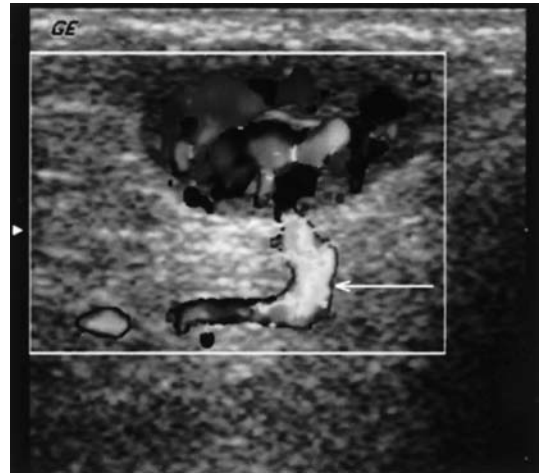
Angioleiomyoma. Color Doppler image shows a well-defined subcutaneous soft tumor with high Doppler flow. This technique is the modality of choice to differentiate between slow and high flow in these vascular tumors. The afferent vessel is conspicuous (*arrow*)
